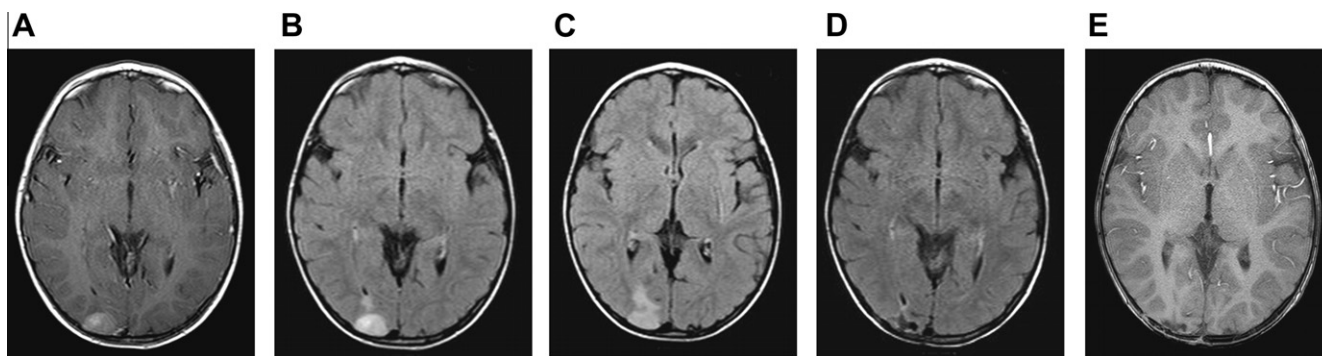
Axial imaging studies in a 3.5-year-old male (patient 1): (A–C) preoperative T1-weighted, gadolinium-enhanced MRI showing a round hyperintense enhancing mass in the right parieto-occipital region; and (B, C) preoperative T2-weighted fluid-attenuated inversion recovery (FLAIR) MRI; and (D, E) postoperative (D) FLAIR and (E) T1-weighted, gadolinium enhanced MRI showing total resection of the tumor.
